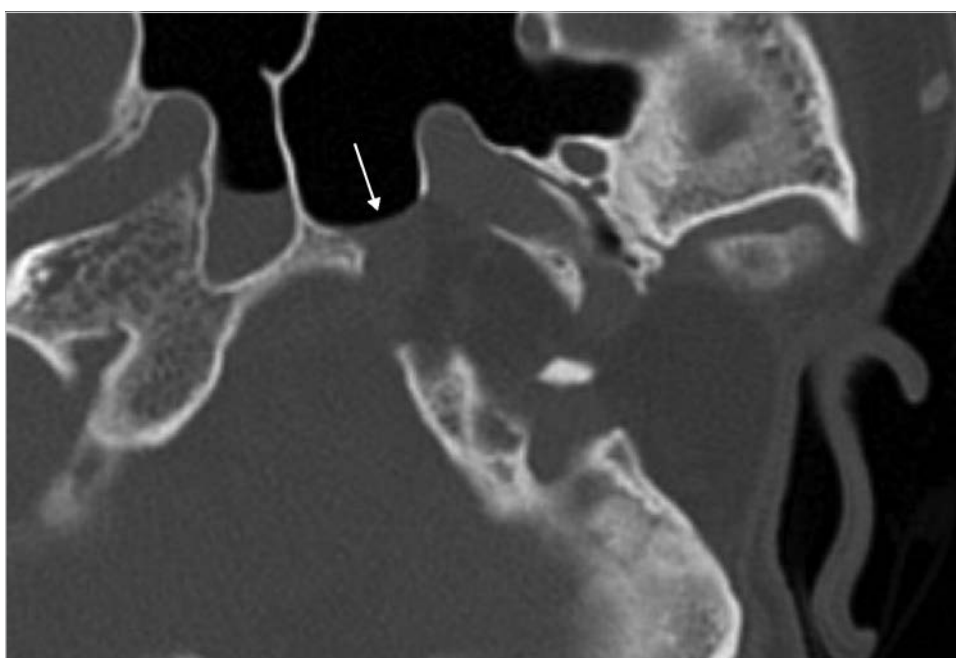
Postoperative CT 4 years after the surgery shows complete closure of the opening in the petrous apex to the sphenoid sinus (*arrow*).
